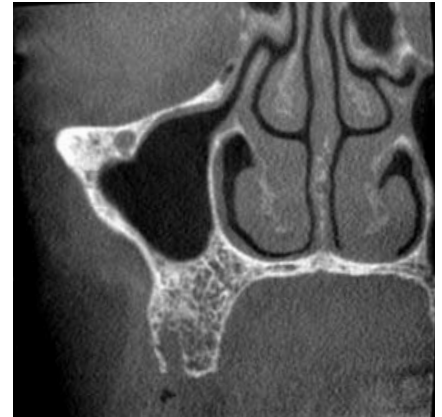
Coronal CBCT slice
